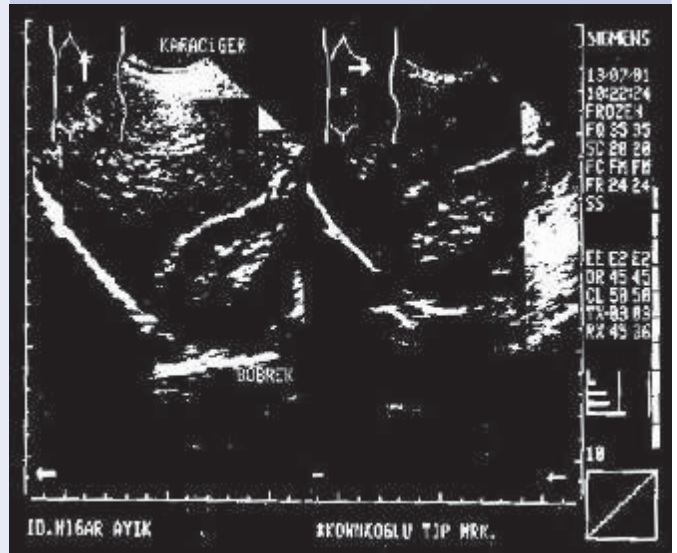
Ultrasound showed left-sided liver.
